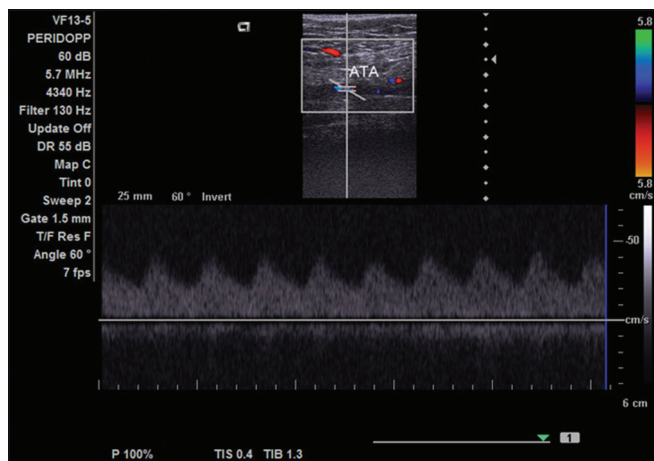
Longitudinal color Doppler image of post-stenotic segment of anterior tibial artery showing low resistance flow pattern
